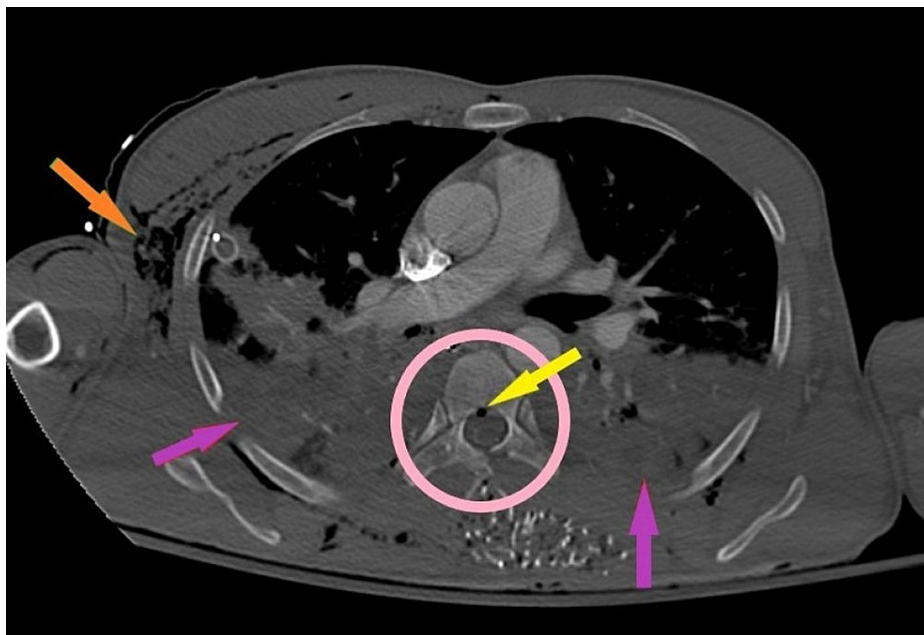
Contrast-enhanced CT with an axial bone window of the chest.
